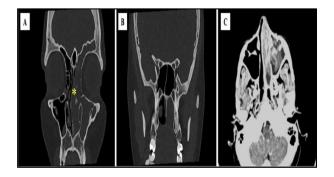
(A & B) Coronal cuts of non-contrast enhanced computed tomography (NCCT) PNS showing hyperostotic focus (indicated in yellow asterisk in left maxillary ethmoid and frontal sinus opacification, with non-involvement of sphenoid sinus, (C) axial view of Contrast-enhanced computed tomography (CECT) PNS complete soft tissue opacification with polypoidal thickening within the left maxillary sinus.
